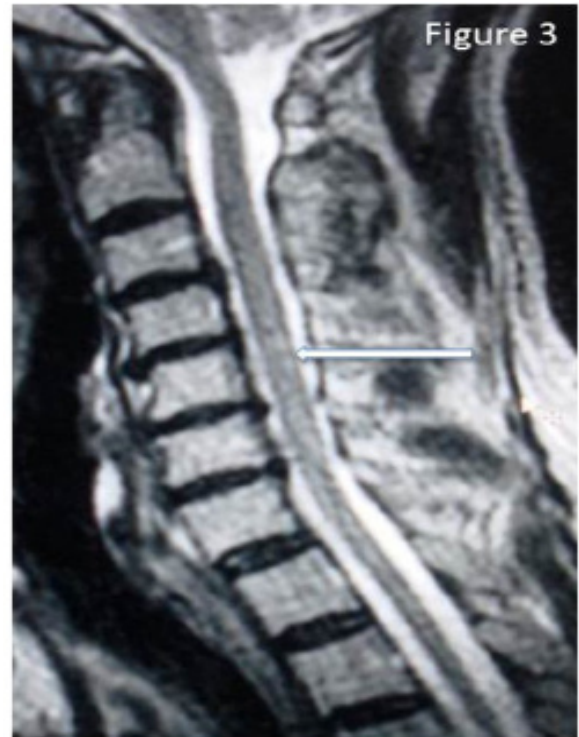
MRI cervical spine sagittal T2 showing hyper intensity involving posterior column at C3 - C5 levels
